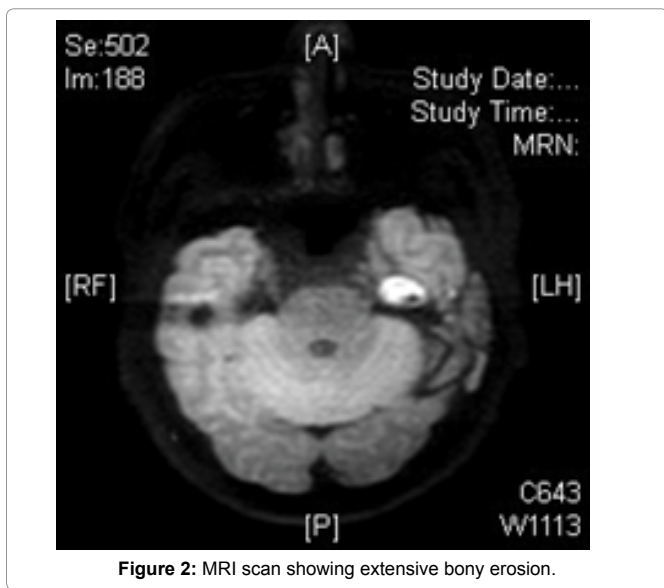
MRI scan showing extensive bony erosion.
